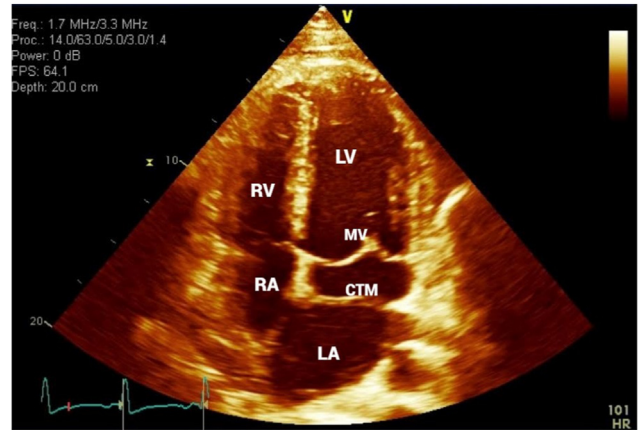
Two-dimensional TTE, apical four-chamber view, systolic phase performed 8 years before the current presentation, demonstrates the cor triatriatum membrane (CTM) dividing the left atrium (LA) into true and accessory chambers. LV, Left ventricle; MV, mitral valve; RA, right atrium; RV, right ventricle.
